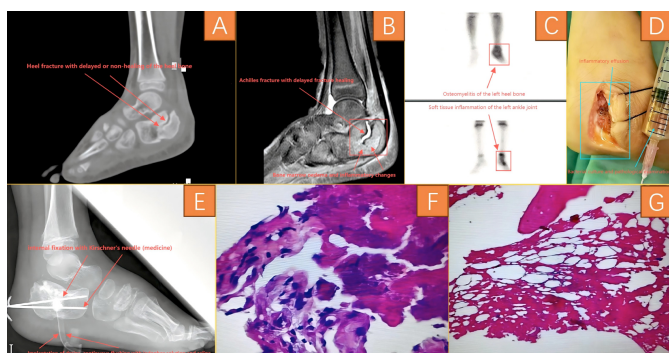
(A) CT scan showing that the left Achilles fracture had not healed, accompanied by soft tissue swelling. (B) MRI showed that the left Achilles fracture had not healed, with high-density images around the fracture, and soft tissue oedema. (C) An emission CT (ECT) bone scan and bone triple-phase showed that there was an increased radiological uptake of the left Achilles and left ankle joint. Radiation uptake was unevenly increased, and in combination with bone triphasic examination, osteomyelitis changes were considered along with soft tissue inflammation around the left-heel bone and left-ankle joint. (D) The fluid was extracted for bacterial culture. (E) X-ray examination showed the fracture was in good alignment, the Kirschner pin was in good position, and the drainage tube was clear. (F, G) Pathological examination showed inflammatory exudates, necrotic bone tissue as well as soft tissue.
